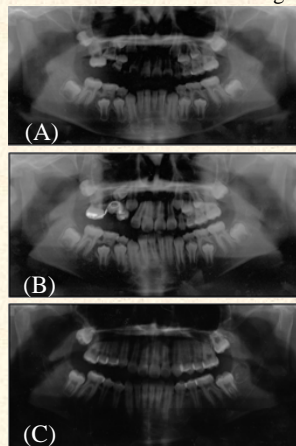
Panoramic radiographs: (A) pretreatment, (7y9m), (B) the upright of upper right first molar (7y11m), and (C) after initial treatment of right posterior teeth (8y5m).
